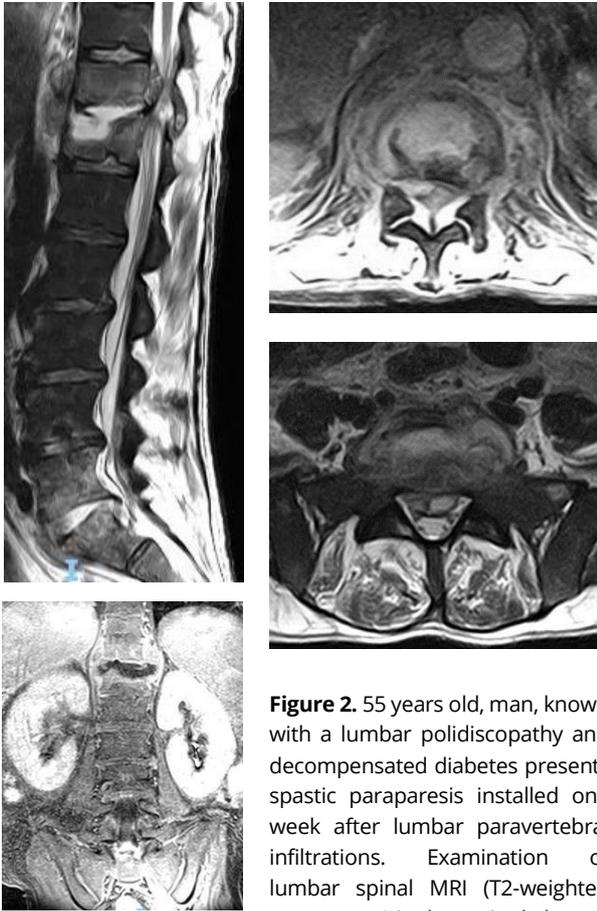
55 years old, man, known with a lumbar polidiscopathy and decompensated diabetes presents spastic paraparesis installed one week after lumbar paravertebral infiltrations. Examination of lumbar spinal MRI (T2-weighted sequences A in the sagittal plane, B
